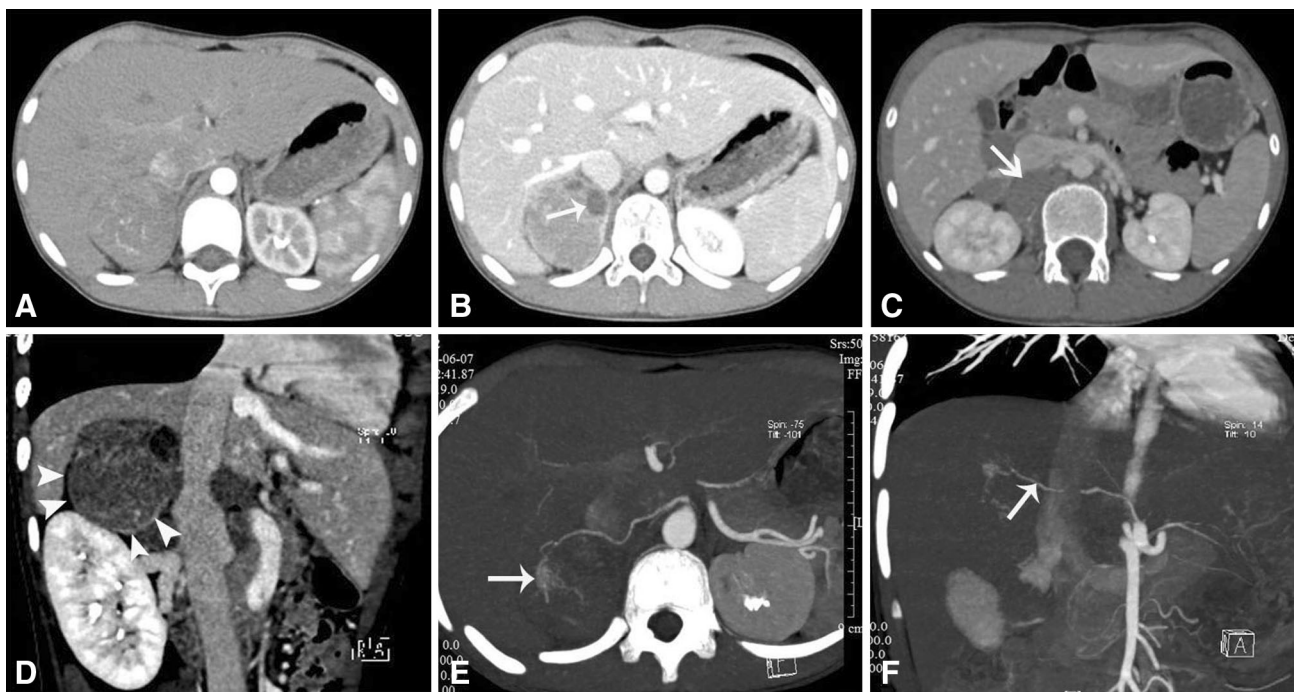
CT findings of a 12-year-old man with an adrenal PNET (case 1). The enhanced CT images showed a well-defined, rounded, solid mass in the region of the right adrenal gland (a, b). The tumor displayed mild heterogeneous enhancement in the arterial and venous phases (a, b) with patchy cystic degeneration areas (b arrow).
